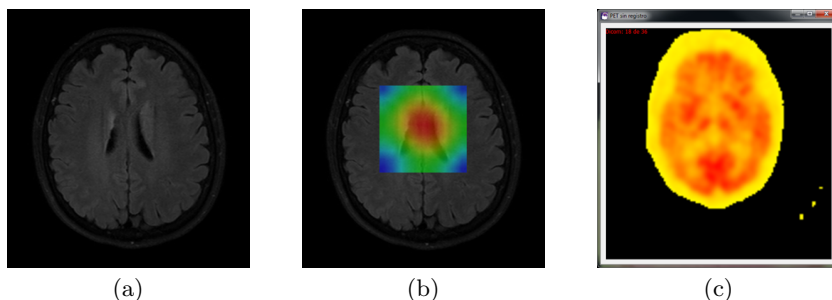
Medical Imaging Modalities in IMFUTEC: (a) MRI, (b) CSI, (c) PET.
